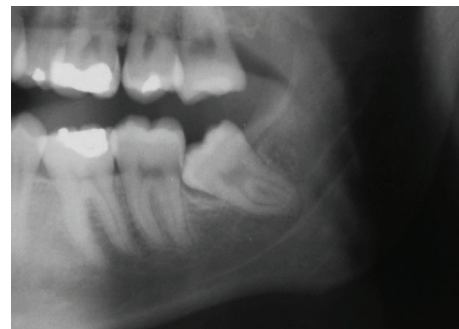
Radiograph of radiographic distal cervical burnout potentially misinterpreted as distal cervical caries.
